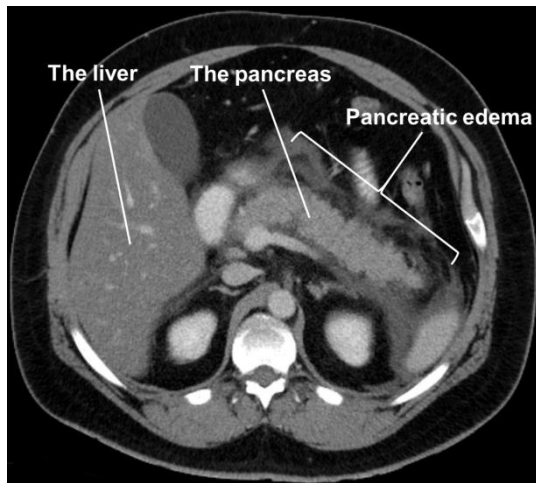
Computed tomography scan of a patient with acute pancreatitis. The pancreatic edema gives the pancreas a “blurry” appearance. Modified from Wikimedia Commons ([commons.wikimedia.org/wiki/File:Pankreatitis\\_exsudativ\\_CT\\_axial.jpg](https://commons.wikimedia.org/wiki/File:Pankreatitis_exsudativ_CT_axial.jpg)) (CC BY SA).
